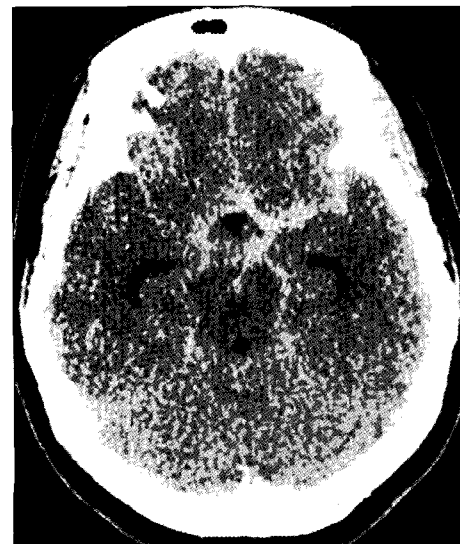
Preoperative computed tomography images show diffuse subarachnoid hemorrhage in suprasellar, ambient, and both Sylvian cisterns.
